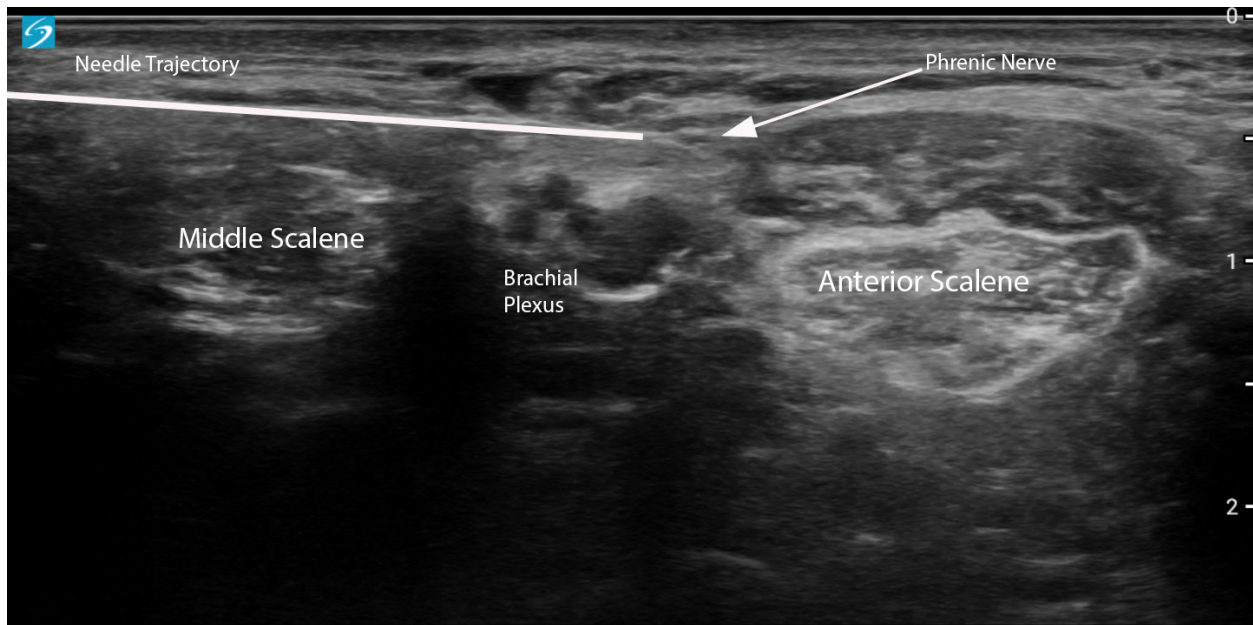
Ultrasound image demonstrating in-plane needle advancement toward the left phrenic nerve for temporary peripheral nerve stimulation lead placement. The anterior scalene, middle scalene, brachial plexus, and phrenic nerve are identified.
